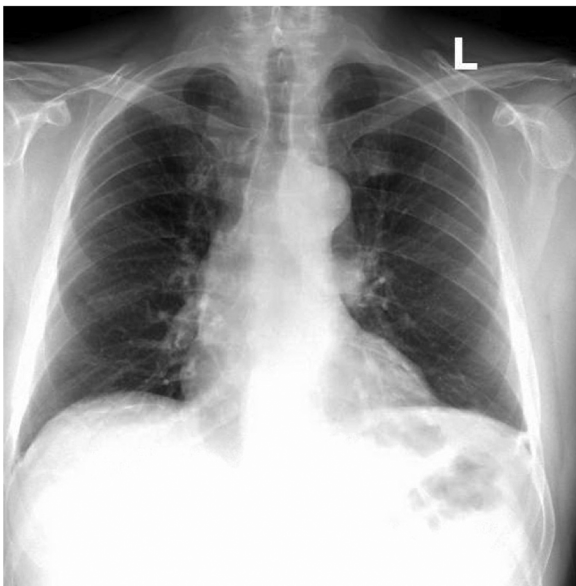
Postero-anterior (PA) chest X-ray.
